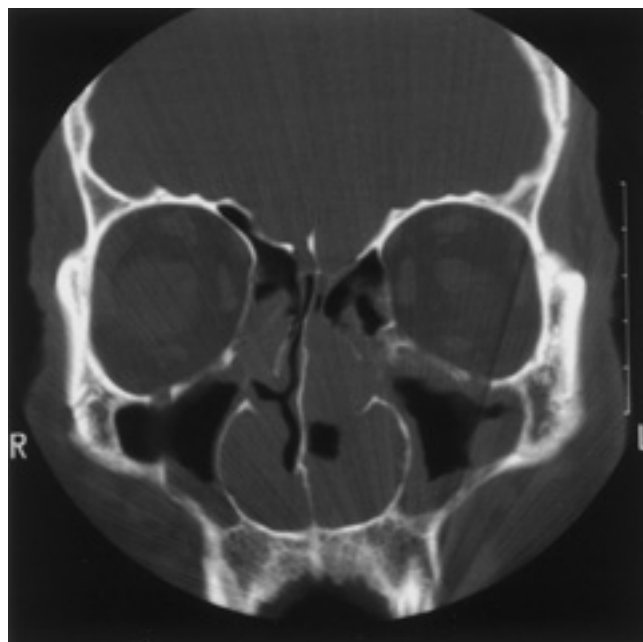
Coronal CT-scan from the second case showing an obstruction of the anterior ethmoid with thickness of the mucosa especially of the left maxillary sinus.
